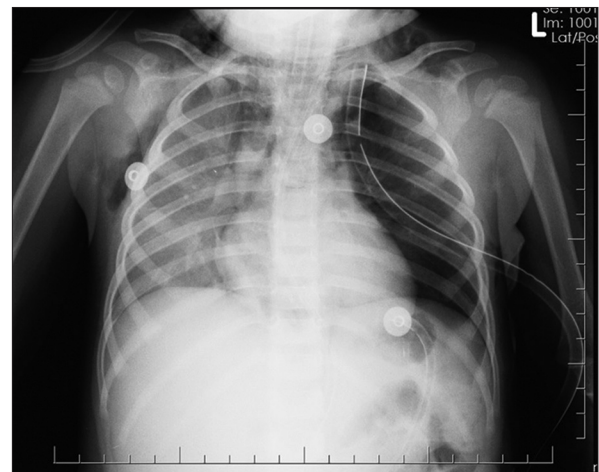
The chest radiograph that was taken just after tube placement
